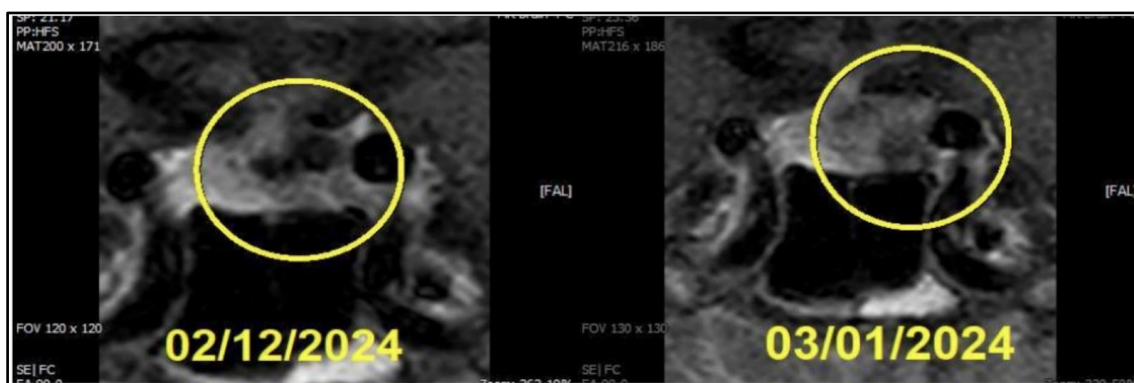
Coronal MRI views of the sellar region demonstrating interval growth of a soft tissue lesion with displacement of adjacent structures and narrowing of the suprasellar cistern.
